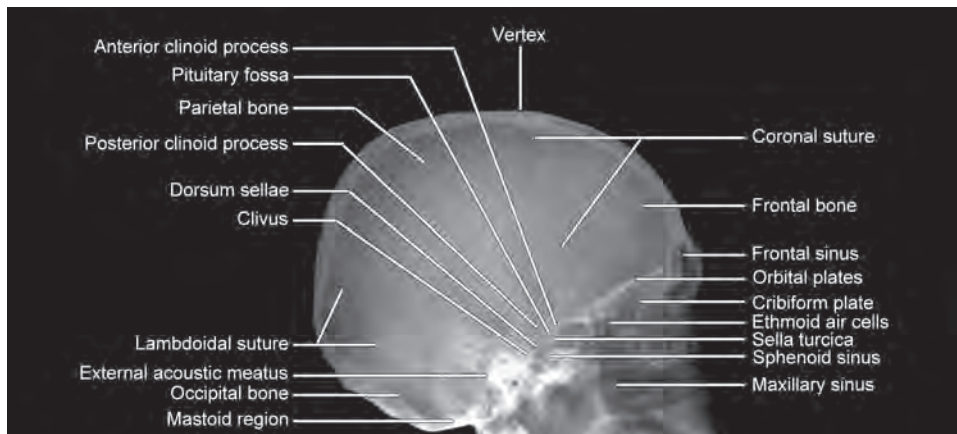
Lateral view of skull X-ray.
